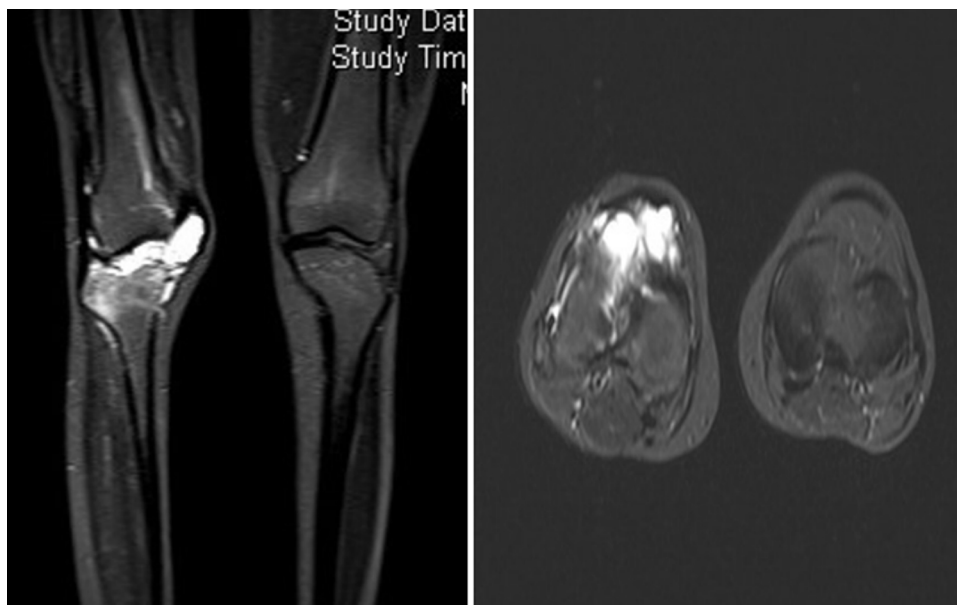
MRI T2 hyper intense lesion with multiple hypo intense septae predominantly within Hoffa's fat pad in favor of slow flow vascular malformation.
